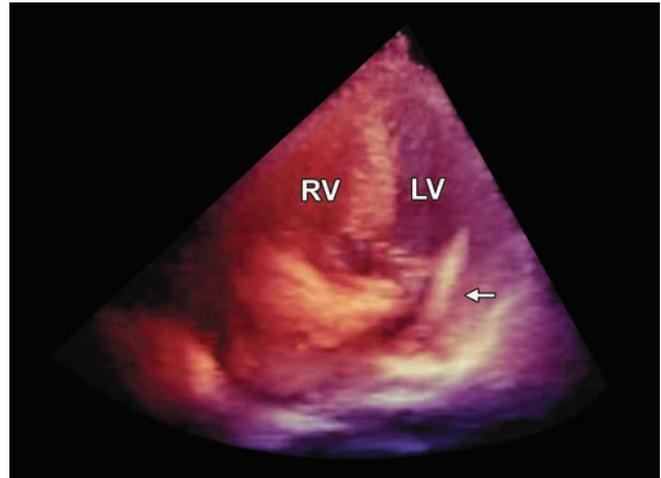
3D transthoracic 4-chamber view.
